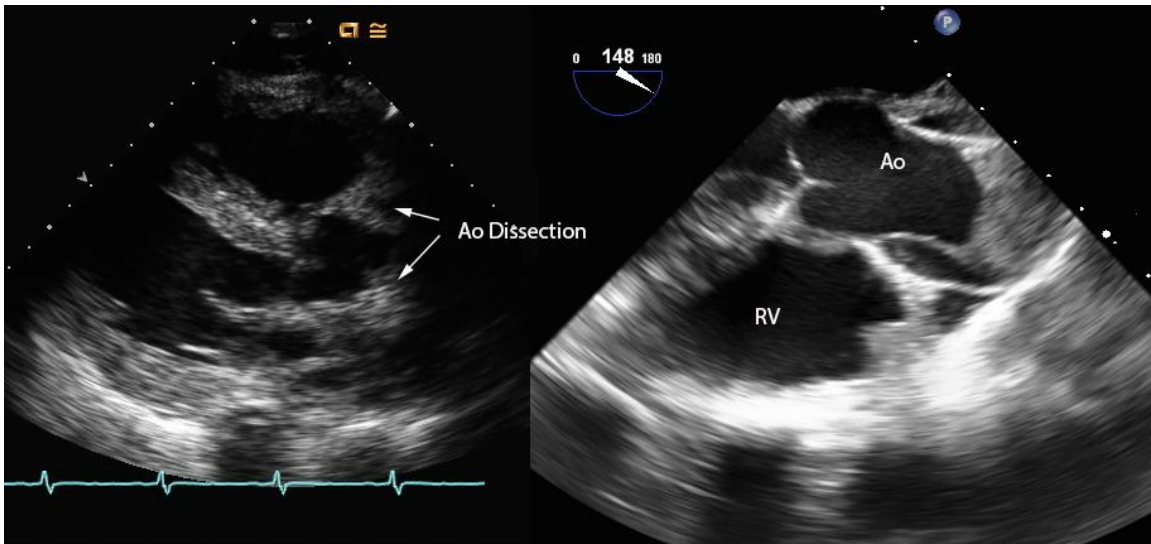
Ascending aortic dissection. Transthoracic imaging of an acute aortic dissection from the parasternal long-axis view in a patient presenting with sudden onset precordial and back pain (left), with poor visualization of the mid and distal ascending aorta. TEE imaging demonstrates the aortic dissection plane, with false lumen seen anterior and posterior to the true lumen, distal to the sinotubular junction (right).
